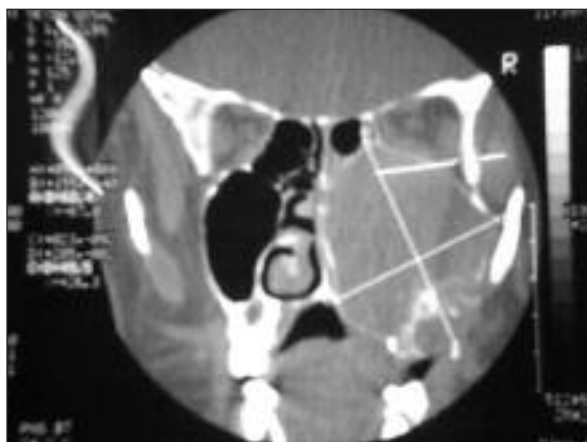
The CT scan shows the iso-hyperdense mass, which occupies the right maxillary sinus and obliterates the right nasal cavity, containing calcifications in its internal structure, indicating contrast medium retention. The mass causes destruction on the anterior and inferior bony structures.
